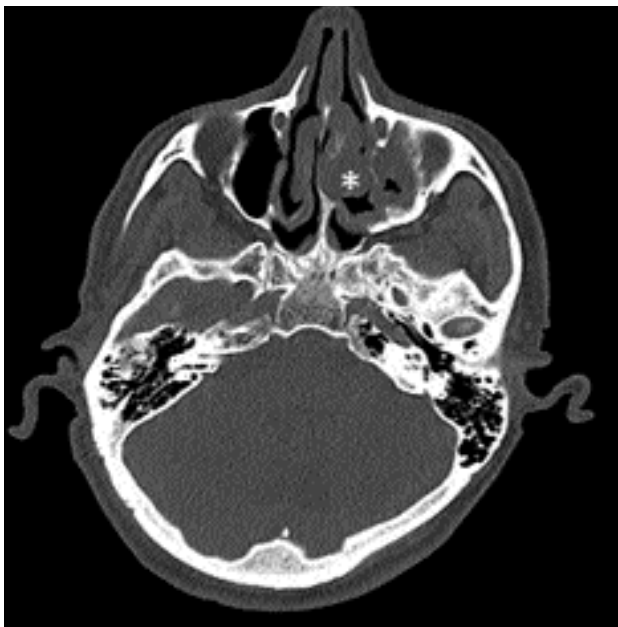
Axial computed tomography scan showing soft-density mass (*) between the lacrimal bone and the middle turbinate.
